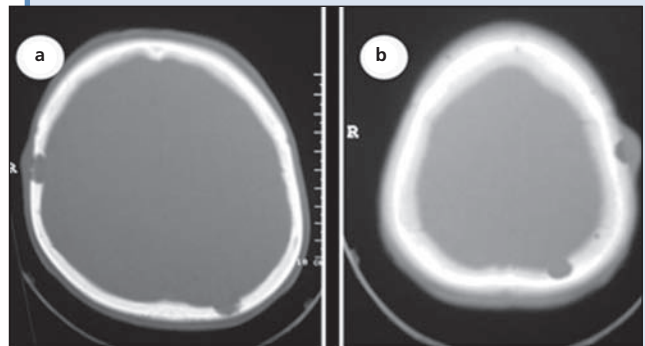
Computed tomography (CT) showing involvement at 3 sites of the skull cap: (a) hard tissue; (b) soft tissue.
